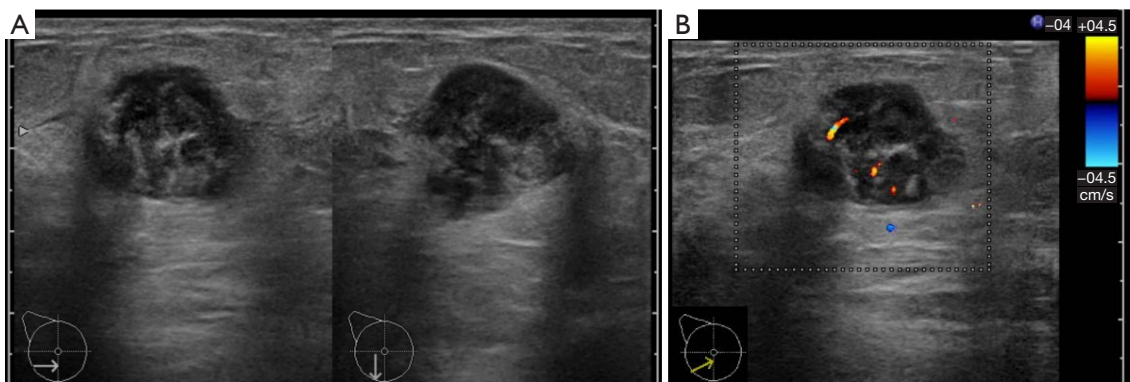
Preoperative ultrasonography findings. (A) Ultrasonography at presentation. (B) Color Doppler imaging. There was a lobulated, hypoechoic, 22 mm × 17 mm × 22 mm mass with blood flow in the right breast.
